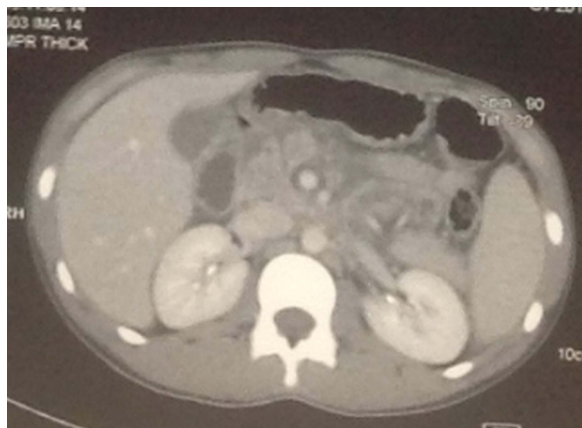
Contrast-enhanced CT of the abdomen with intravenous contrast showing the proximally transected pancreas.
